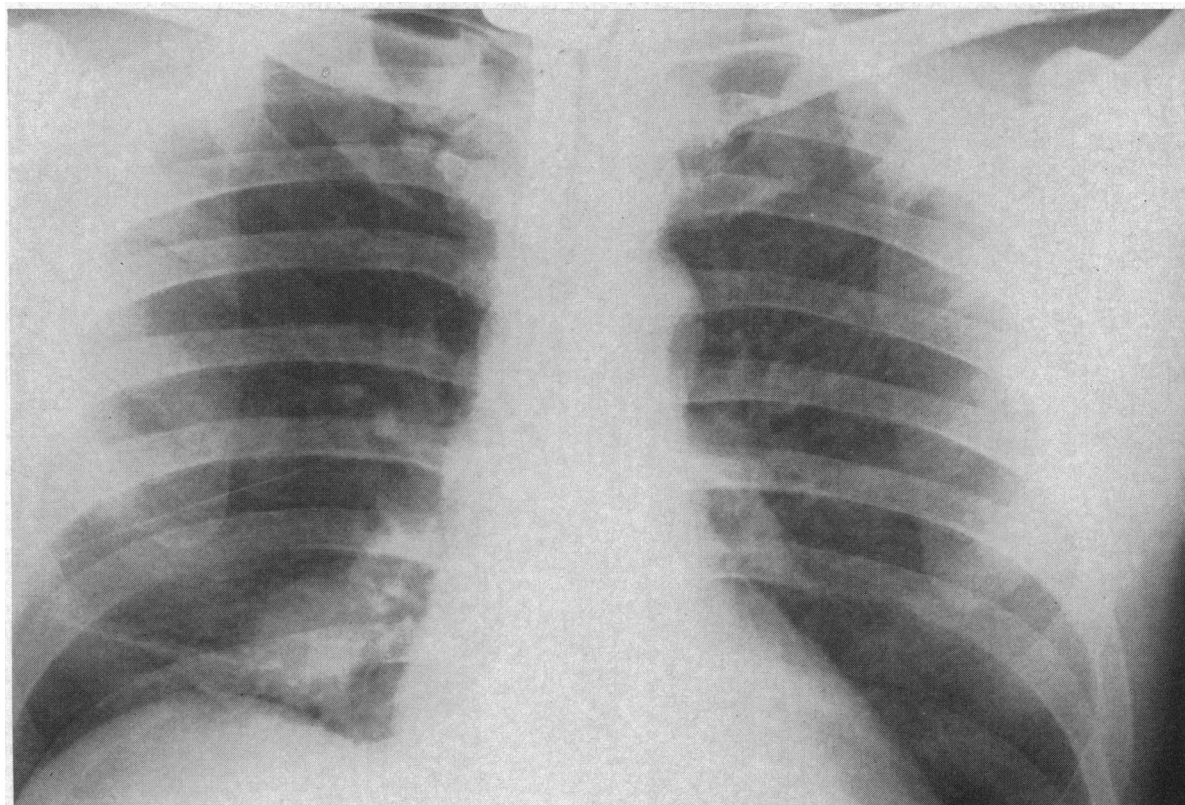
X-ray film taken five days later after admission. Note lesion at right base.
